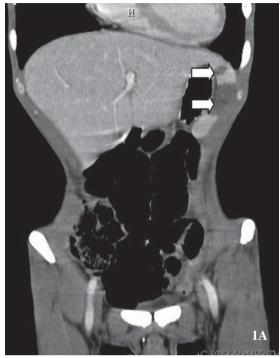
CT with contrast of the abdomen shows multiple wedge-shaped and nonenhancing hypodense areas (arrows), with splenic infarction being noted.
